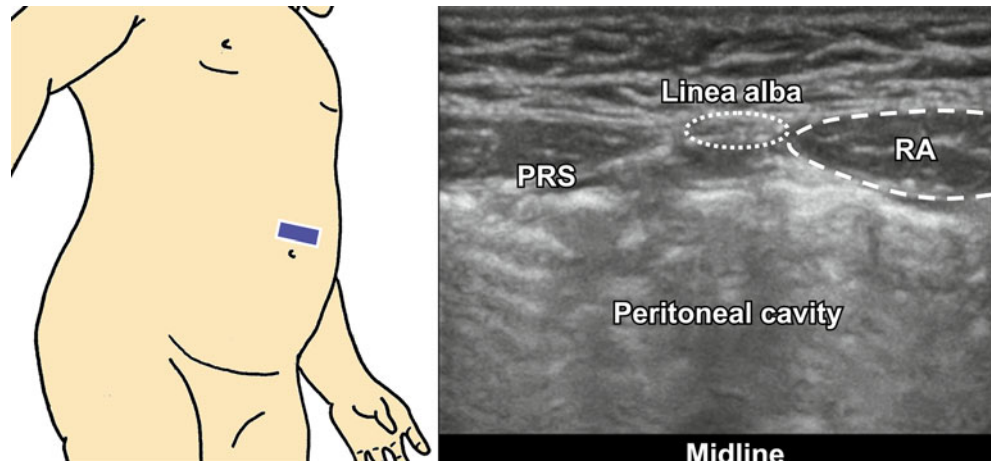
Ultrasound image of the abdominal wall and rectus sheath. *PRS* posterior rectus sheath, *RA* rectus abdominis muscle
